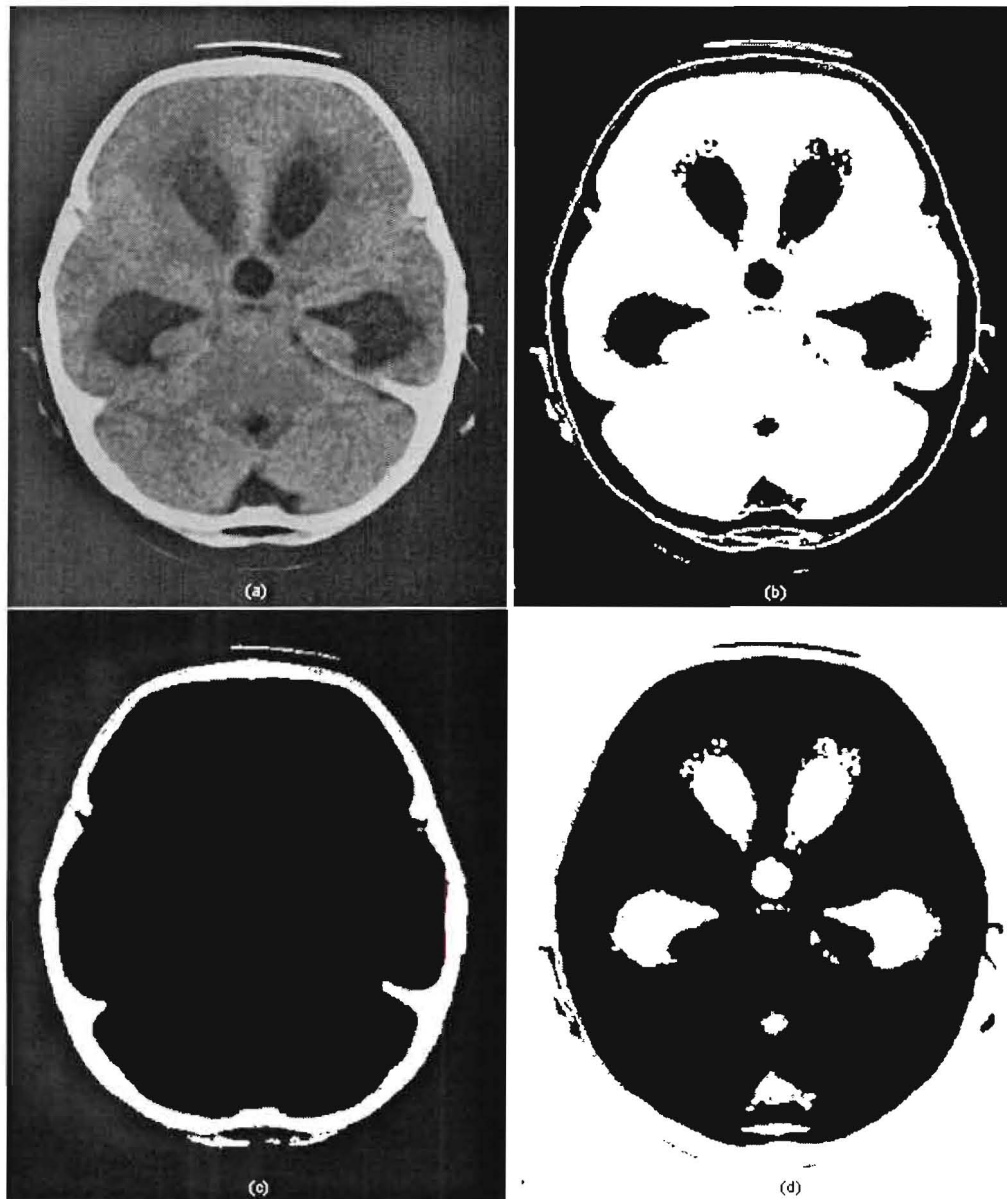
Showing the Original CT image and the resultant clusters after undergoing our unsupervised optimal fuzzy clustering. Image (a) is the original CT image after undergoing pre-processing. Image (b) shows the 'brain' cluster resulting from the UOFC algorithm. Image (c) shows clearly the 'skull' cluster and image (d) shows the 'ventricle' cluster.
